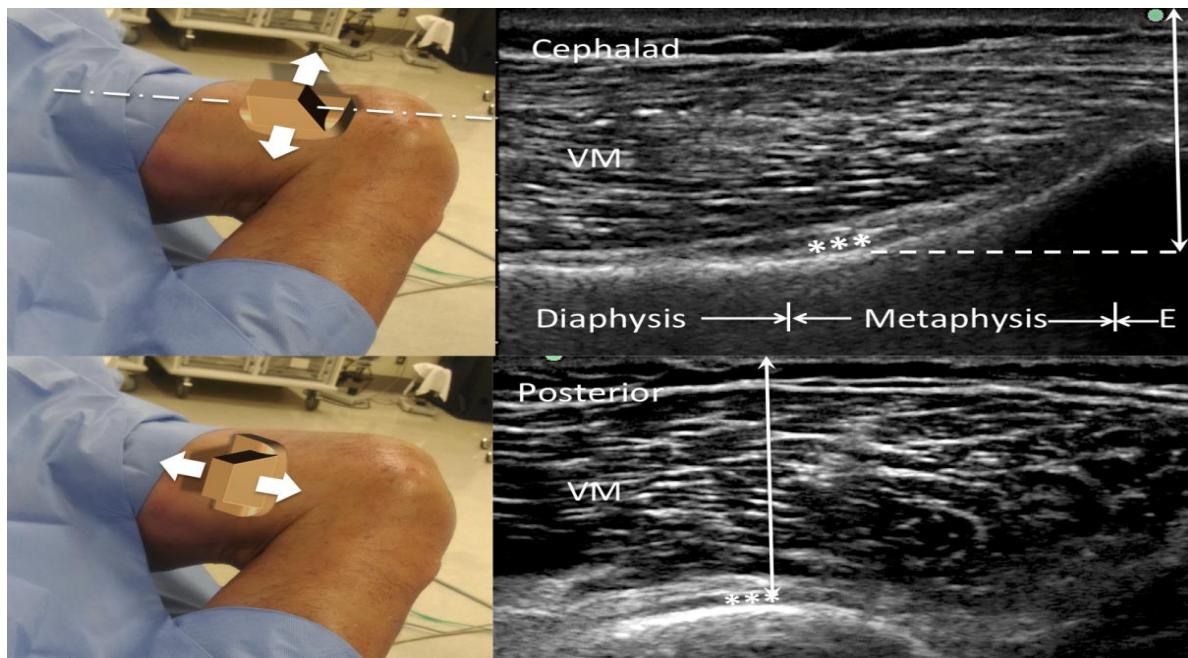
Classical Landmarks Using Ultrasound Probe [65]
